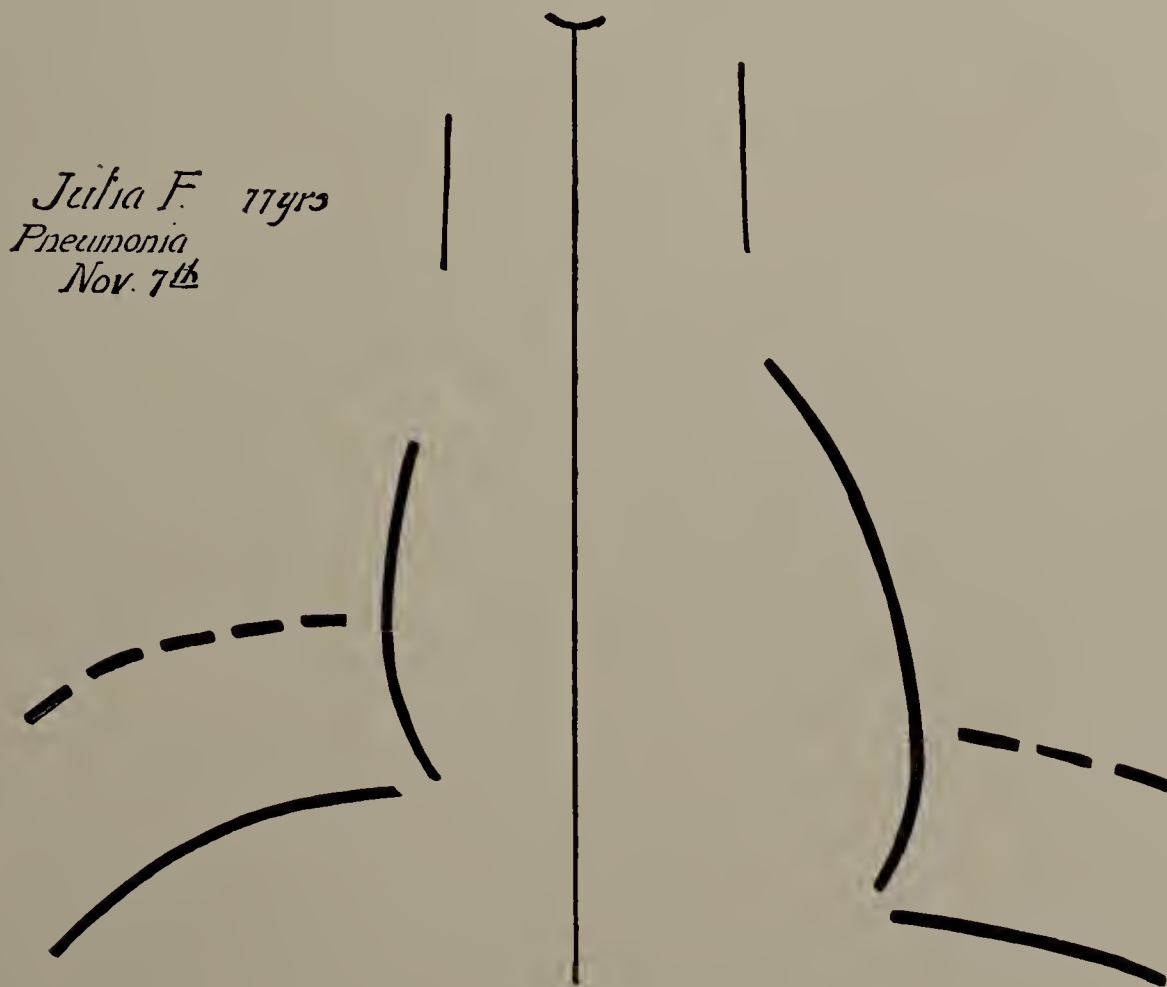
Julia F. November 7. Second X-ray tracing. Lung clear; diaphragm lines seen. (One-third life size.)
